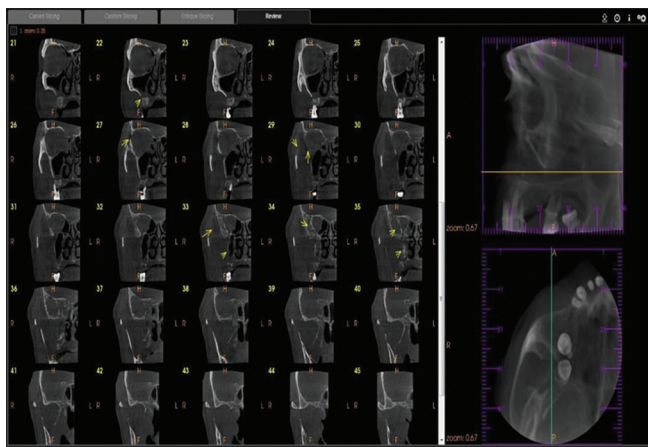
Cone beam computed tomography of right orbital region
